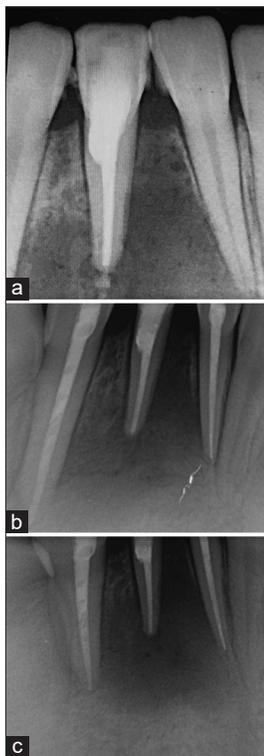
Endodontic management and follow-up: (a) Postoperative radiograph, (b) 12-month follow-up, (c) 24-month follow-up.
